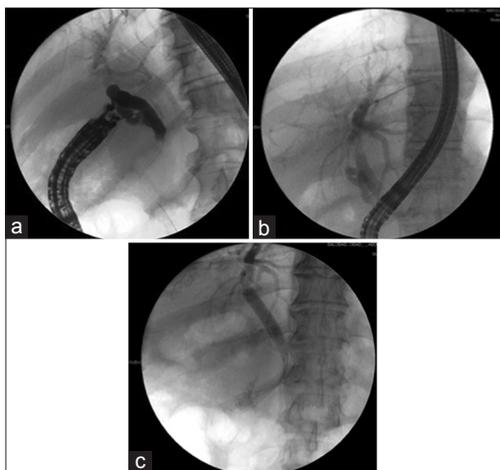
(a) A needle is introduced through the duodenal wall into the common bile duct and after confirmation of the position with contrast injection a wire is introduced through the needle and manipulated to reach the duodenal lumen through the papilla. (b) Cannulation is achieved with a regular duodenoscope after removing the endoscopic ultrasound scope. (c) Final result after deploying a metal stent in the biliary system
